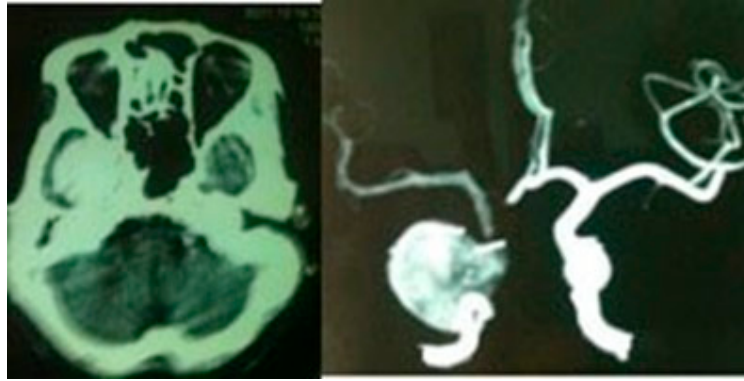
CT scan showing a giant cavernous carotid aneurysm on the left. CT angiogram showing a giant cavernous carotid aneurysm on the right side. Source: Figure by authors.
